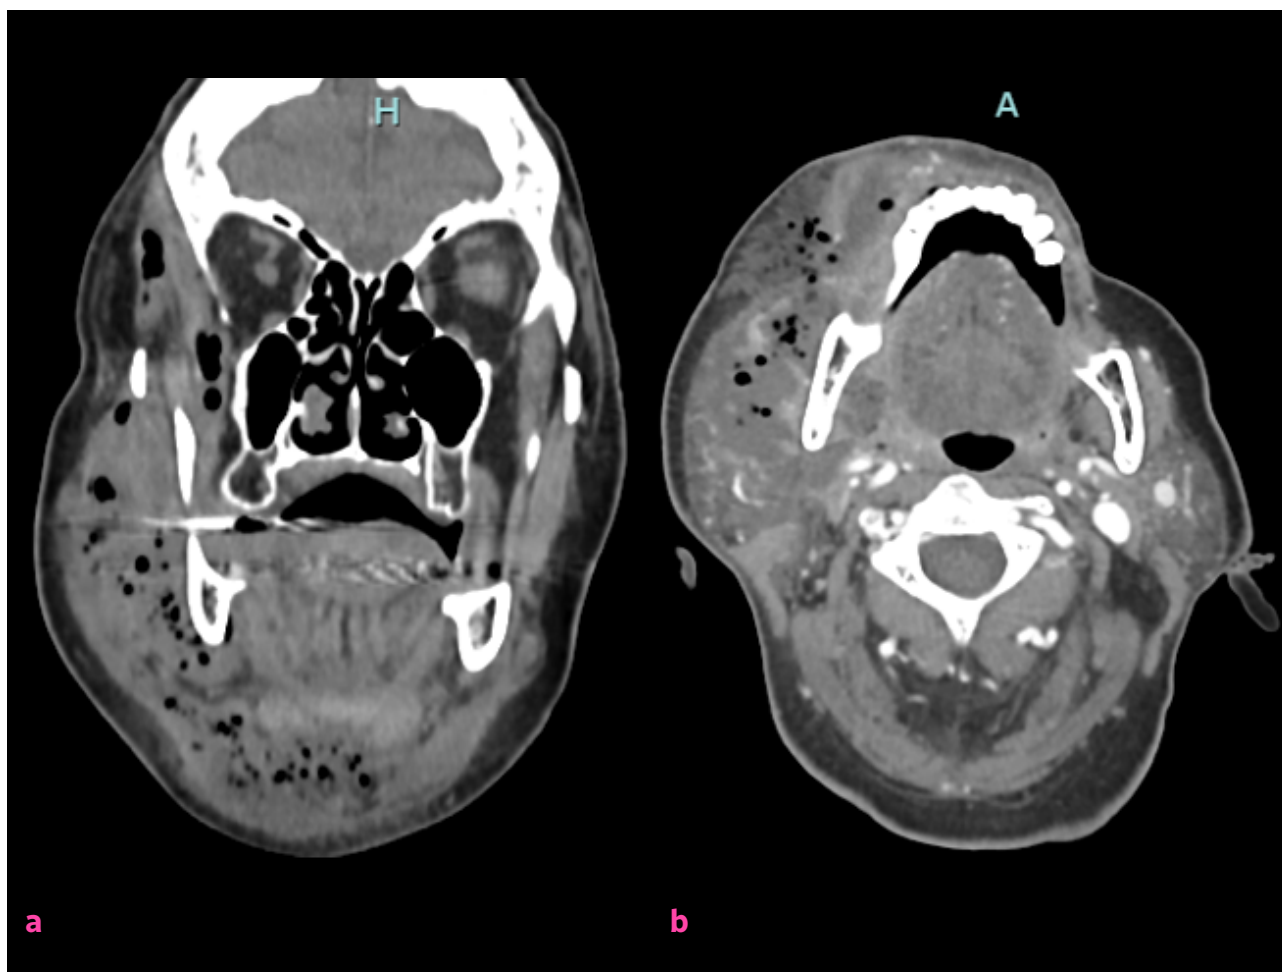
(a and b) Contrast-enhanced CT scans showing coronal and axial sections. Fluid collections are evident in the right temporal, infratemporal, masticatory, sublingual, submandibular, and cervical spaces, as well as in the submental space.
